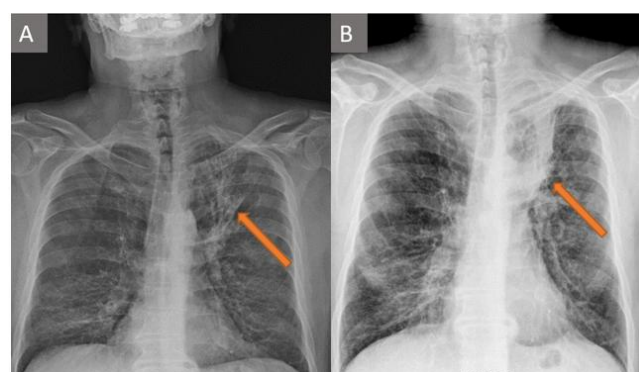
In the initial chest X-ray, densities can be seen in the upper zone of the left lung and the lower zone of the right lung (A). In a follow-up chest X-ray after discharge, a newly developed density can be seen in the upper zone of the left lung (B)
